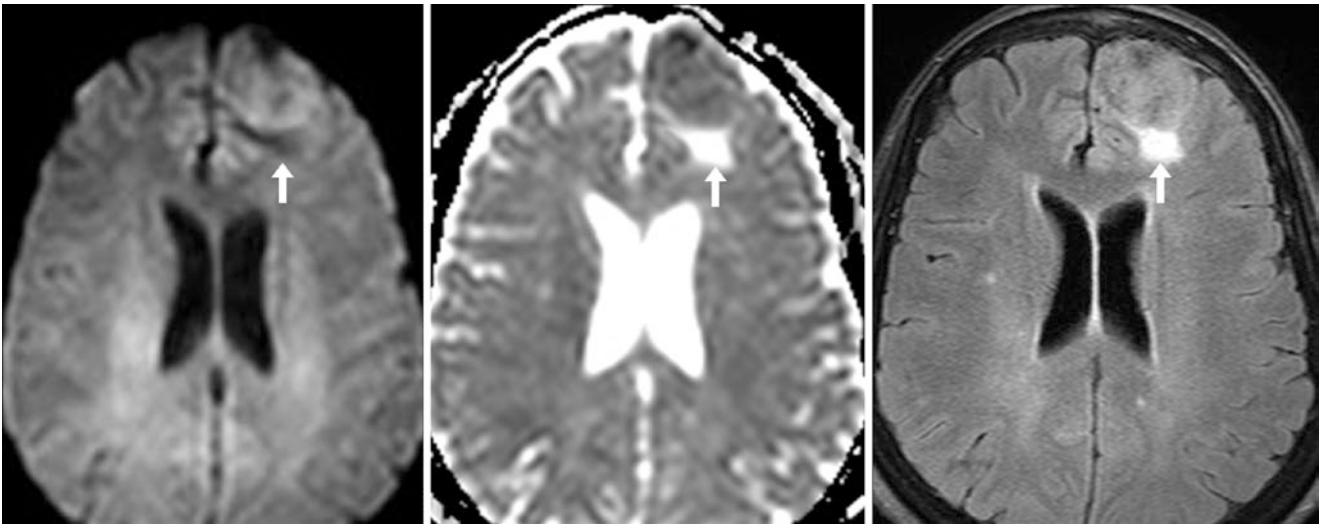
A 64-year-old with a high-grade oligodendroglioma. A 3 T MRI showed avid contrast enhancement on T1WI (not shown), with dark signal from T2 washout on DWI (*left*), caused by peritumoral
